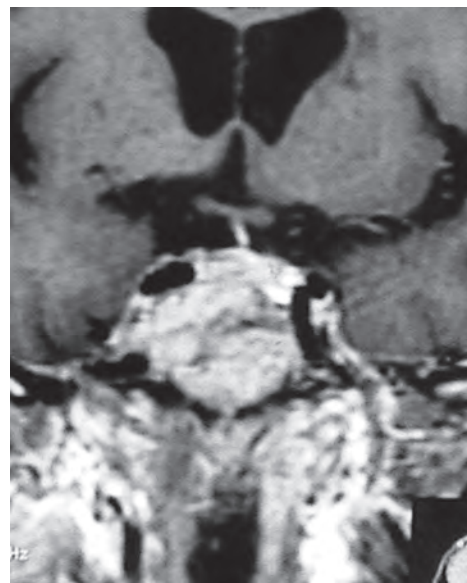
T1-weighted contrast enhanced coronal image showing the same lesion
